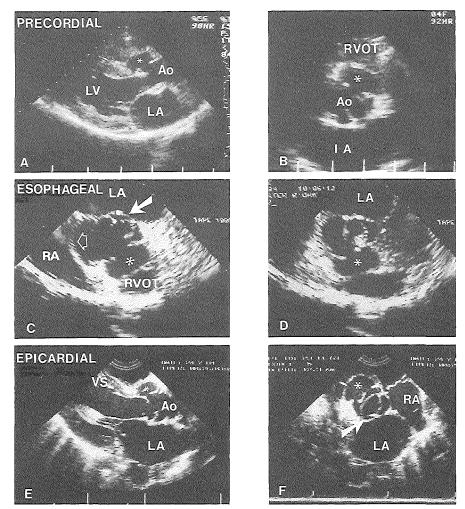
Two-dimensional echocardiograms obtained from precordial (A,B), esophageal (C,D), and intraoperative epicardial transducer positions (E,F). The mycotic aneurysm is indicated in all the cross sections by an asterisk, and it is bounded by remnants of the original annulus. It has open communication with the aortic lumen (Ao) and is bordered inferiorly by the interventricular septum (VS) and anteriorly by the right ventricular outflow tract (RVOT). A large vegetation is seen on the right aortic cusp (A,D, and E). The esophageal study revealed that the aortic wall near the noncoronary cusp, adjacent to the right atrium (RA), demonstrated prominent systolic expansions (C; open arrow). A fourth aortic cusp is seen on panels C and F (see arrow).
